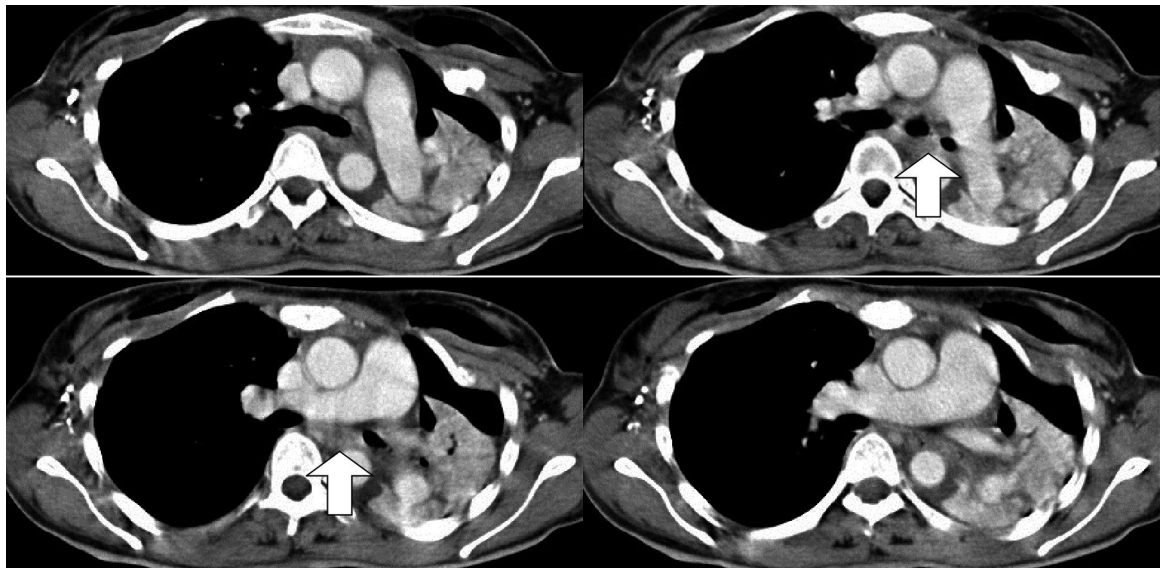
Serial axial contrast CT scan images on PTD 32 revealed a plug (arrow) about 2 cm in length in the midway — at the middle of the left main bronchus with left lung obstructive pneumonitis and total collapse.
